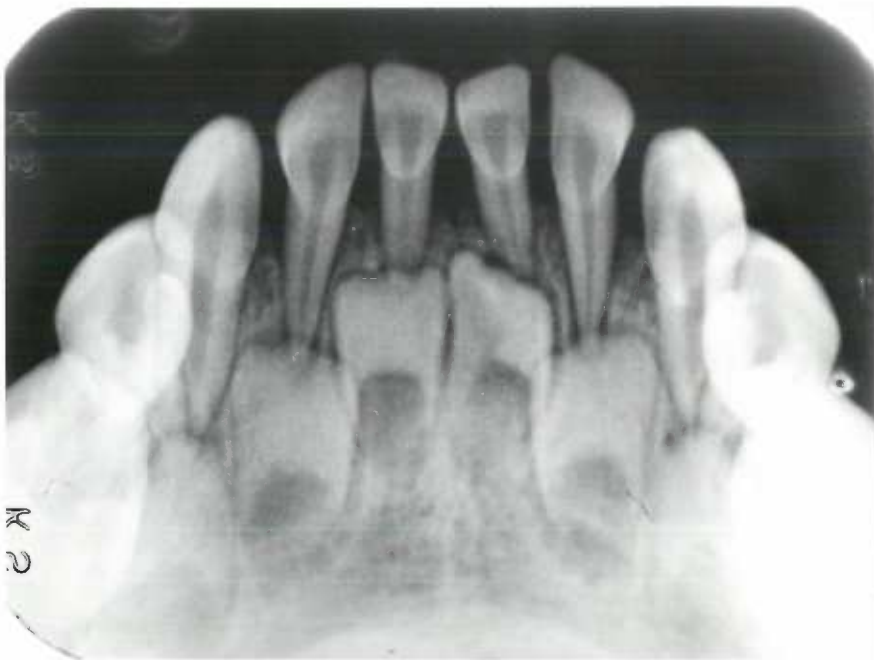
Patient 2. Age three years, radiograph of lower anterior area shows moderate alveolar bone loss.
